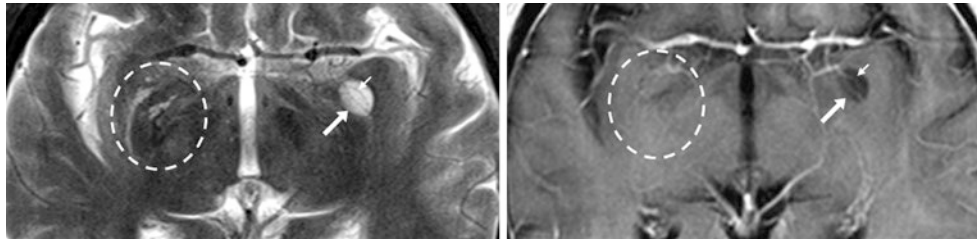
A 65 year old had a dilated PVS (*arrows*) of the left anterior perforated substance on T2WI at 3T (*left*) and on postcontrast T1WI (*right*); it suppresses on FLAIR (*not shown*). There are tiny perforating vessels (*tiny arrows*) that traverse the PVS. Additionally, there is an appearance bordering on *état criblé* on the right (*dashed circles*)
